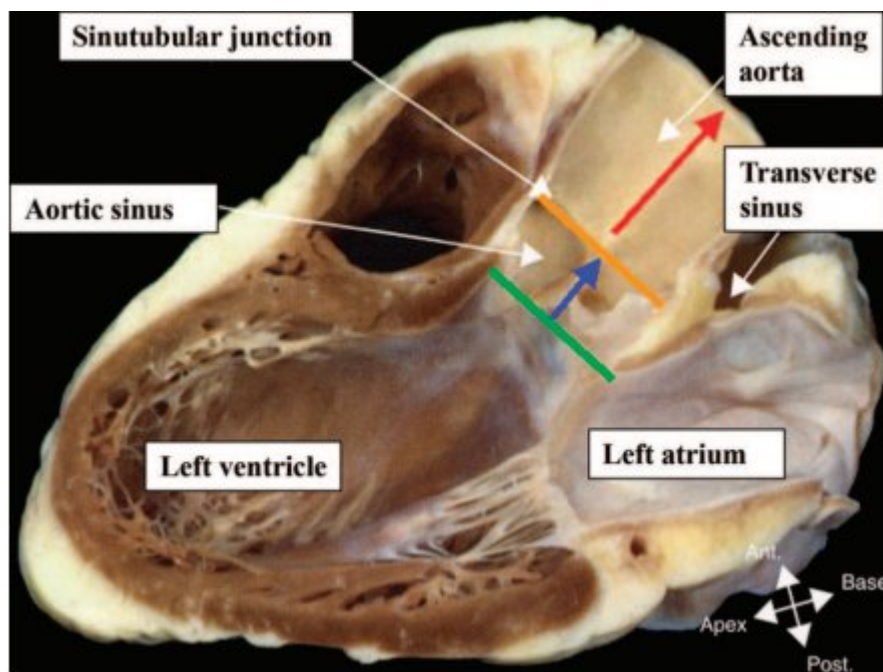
The long-axis view of the left ventricle corresponding with the echocardiographic parasternal long-axis view, demonstrating the extent of the aortic root. AV indicates aortic valve⁽⁶⁾
